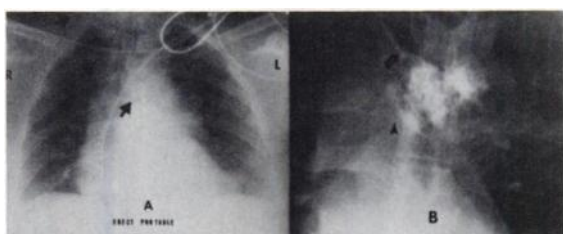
A: Supine erect portable chest radiograph obtained 30 min before \dot{V}/\dot{Q} study; arrows shows course of catheter. Mediastinum is widened. B: Fluoroscopic spot film demonstrating contrast within external jugular catheter (large arrow), and extravasating into mediastinum. Solid black arrowhead locates carina.
